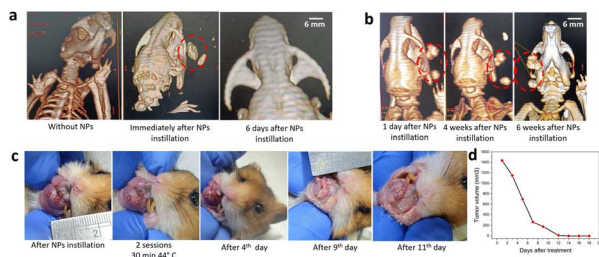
CT scan images of hamsters before and after intratumoral instillation of AS-IONPs: (a) without AMF exposure and (b) with AMF exposure ( $100 \text{ kHz}$  and  $0\text{--}12 \text{ kA m}^{-1}$  varying field). The red dashed circle indicates the injection site ( $100\text{--}150 \mu\text{L}$  of  $150 \text{ mg per mL}$  AS-IONPs). (c) Representative photographs showing oral tumor regression during the treatment period. The intratumoral temperature was monitored using an optical fiber-based thermometer introduced through a cannula. (d) Treatment response curve showing reduction in tumor volume over time.
